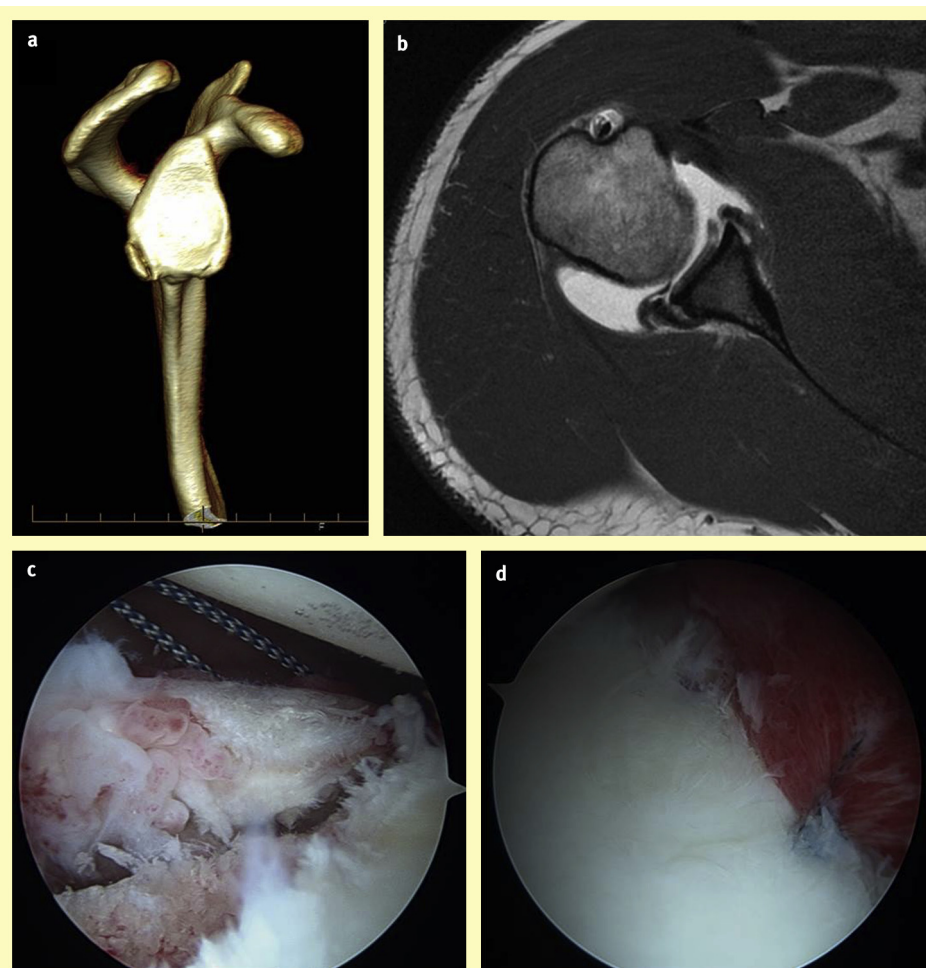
CT reconstruction of the glenoid (a) and MRI arthrogram (b) in a rugby player presenting with an acute posterior dislocation after a front on tackle mechanism of injury. Imaging demonstrated a posterior Bone Bankart lesion, anterior labral tear and what appears to be a healed anterior bone Bankart lesion, although he did not recall any significant previous shoulder symptoms. Arthroscopic stabilization included mobilization and repair of the anterior Bankart lesion (c) and repair of the posterior bone Bankart injury (d).
